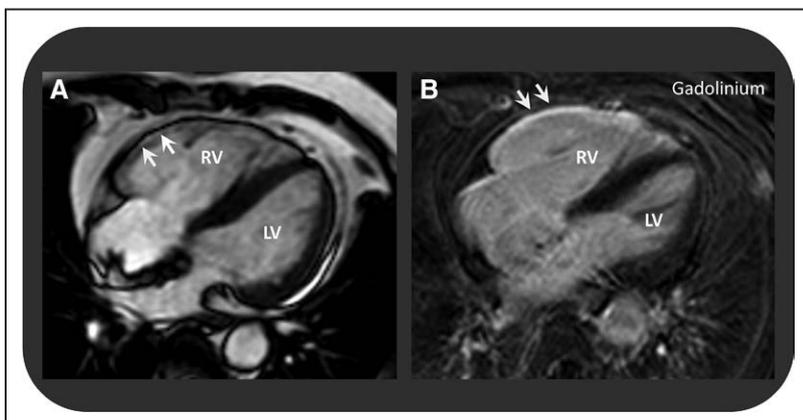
Cardiac magnetic resonance imaging (MRI).
